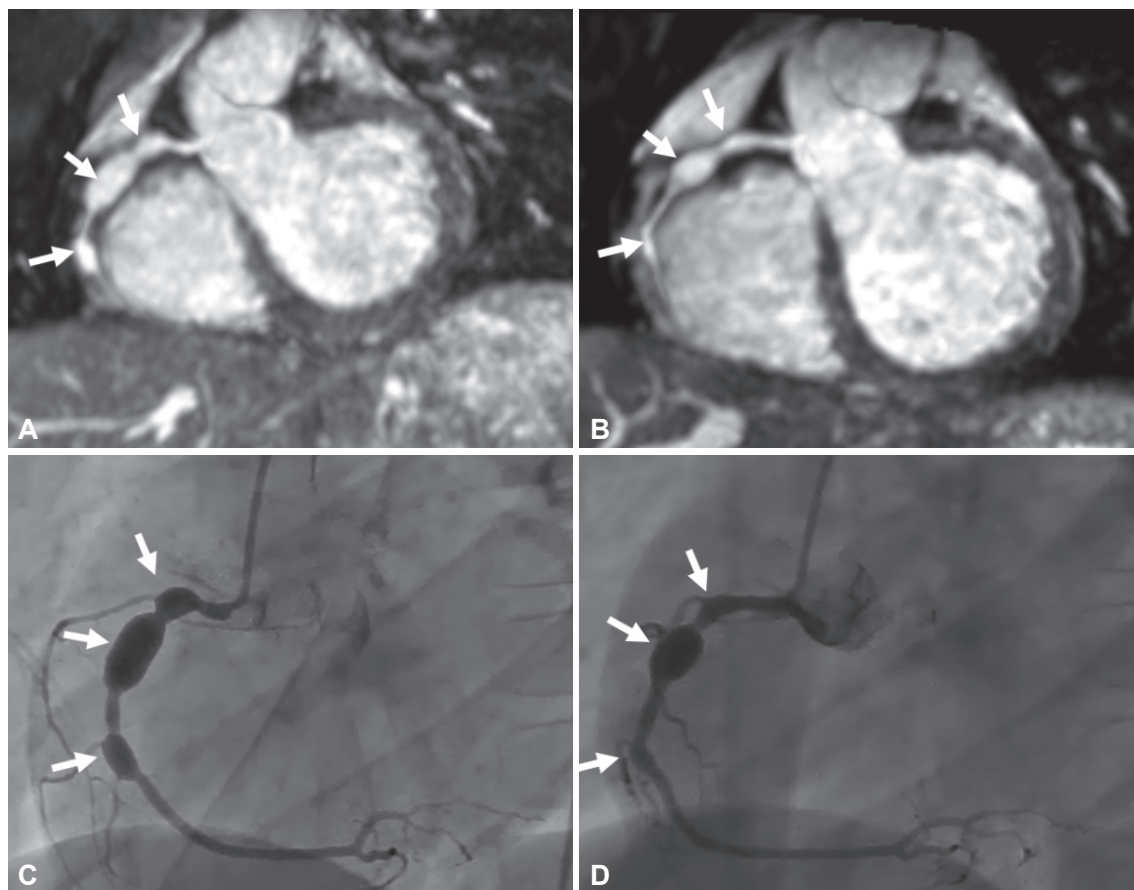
A now 6-year-old child with right coronary artery (RCA) aneurysms secondary to Kawasaki disease. (A) Thin-slab maximum-intensity projection images of the initial whole-heart coronary MRA showed 3 RCA aneurysms. (B) On follow up MRA, all aneurysms showed significant reduction in size and change of morphology. (C and D) Corresponding X-ray coronary angiography shows the same changes. MRA: magnetic resonance angiography.
